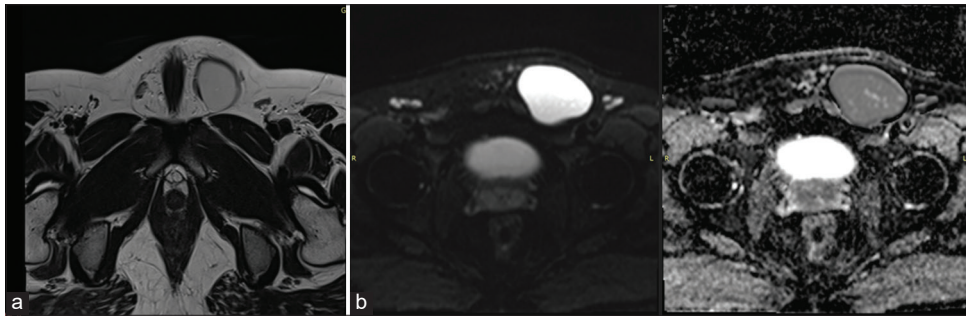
(a) Axial T2-weighted magnetic resonance imaging (MRI) image showing a well-defined hypointense cystic lesion within the left inguinal canal (arrow), located along the expected course of the spermatic cord; (b) diffusion-weighted MRI demonstrating marked diffusion restriction within the lesion (arrow), consistent with dense keratinous contents typical of an epidermoid cyst
